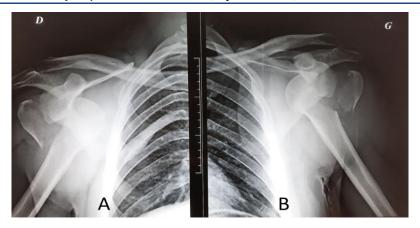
Radiographs showing a bilateral symmetric anterior shoulder dislocation, with a bilateral fracture of the greater tuberosity: A: Right shoulder; B: Left shoulder.
